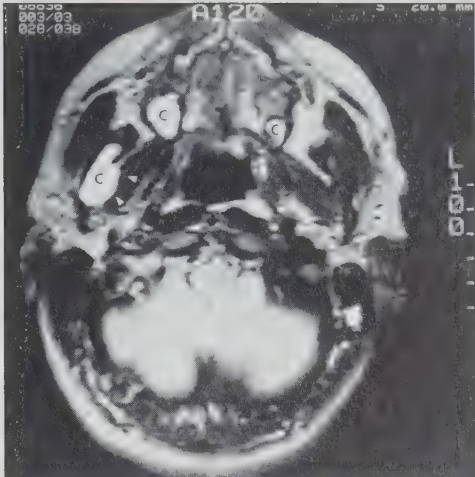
(Case 2): MRI — Axial T1 weighted image. A well-circumscribed high intensity homogeneous lesion is noted in the right mandibular ramus as well as bilateral lesions in the maxillary tuberosity (C). Note the medial cortical perforation and the medial pterygoid muscle displacement (white arrows). Additional cuts demonstrated extensive coronoid and condylar process involvement as well as anterior border perforation.
